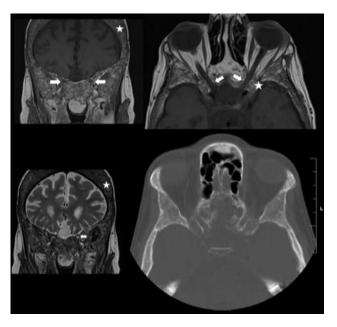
Upper two images: MRI T1-weighted coronal and axial images of the orbits showing diffuse calvarial thickening and expansion of the diploic spaces (star) and generalized marrow hyperplasia involving the maxillary sinuses, sphenoid wings, and clinoid processes. The hypertrophied bone causes crowding and diminished fat at the orbital apices and optic canals resulting in compression of the intracanalicular optic nerves (arrows). Lower left image: MRI T2-weighted coronal images of the orbits with fat suppression showing subtle bright T2 signal changes in the optic nerves, greater on the left. Lower right image: CT axial image of the skull base showing medulary expansion of the bony structures.
